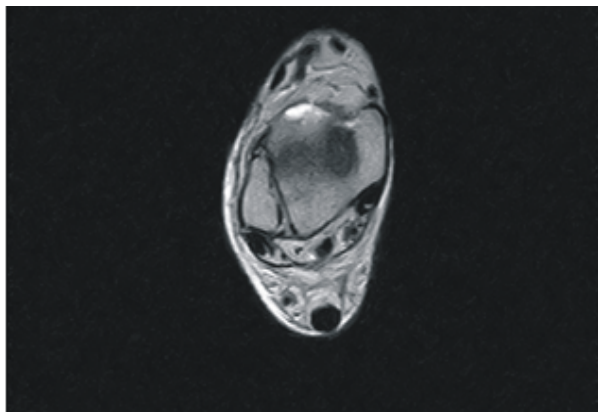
MRI image showing involved area (arrow head)
